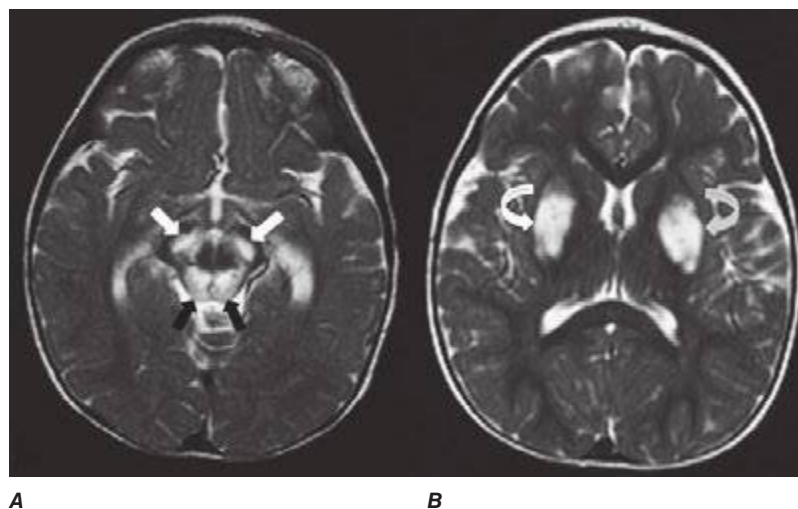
54 Leigh's disease (subacute necrotizing encephalomyelopathy) (Chap. 85e). Axial T2-weighted MRI (A, B) demonstrates increased T2 signal involving the substantia nigra (white arrows) and dorsal midbrain (black arrows), as well as the putamen bilaterally (curved arrows). This is a common pattern for the mitochondrial disorder Leigh's disease secondary to cytochrome oxidase (CO IV) deficiency.
